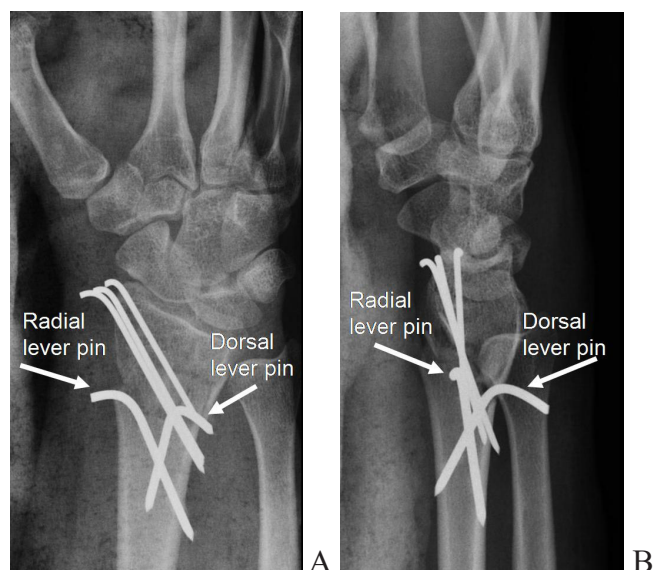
X-ray (A – lateral view; B – p-a view) of the completed fixation using the shortened K-wires
